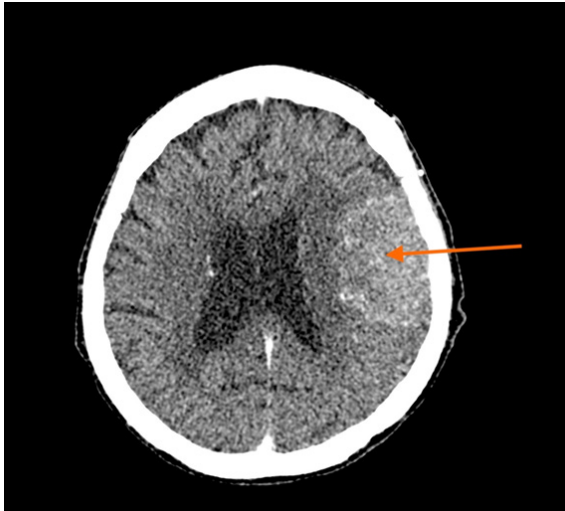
Contrast-enhanced CT brain showing solitary enhancing extra-axial brain parenchymal lesion at frontoparietal region measuring $5.3 \times 3.8 \times 5$ cm (arrow), suggestive of meningioma
